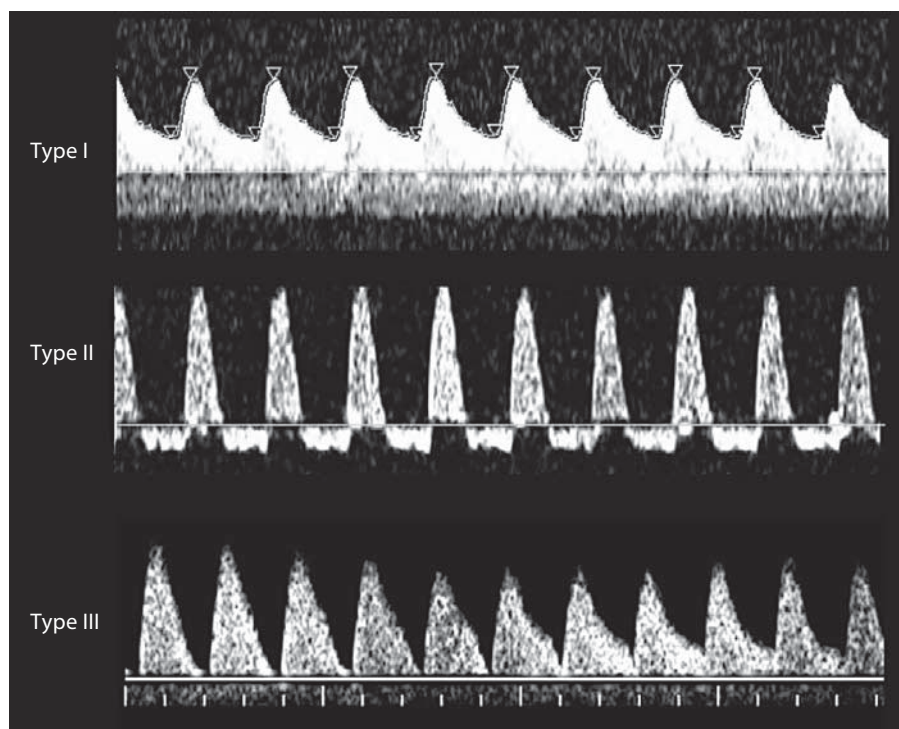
Representation of the three types of discordant growth according to the umbilical-artery Doppler classification of type I with positive end-diastolic flow, type II with persistently absent end-diastolic flow and type III with intermittently absent or reversed end-diastolic flow.
